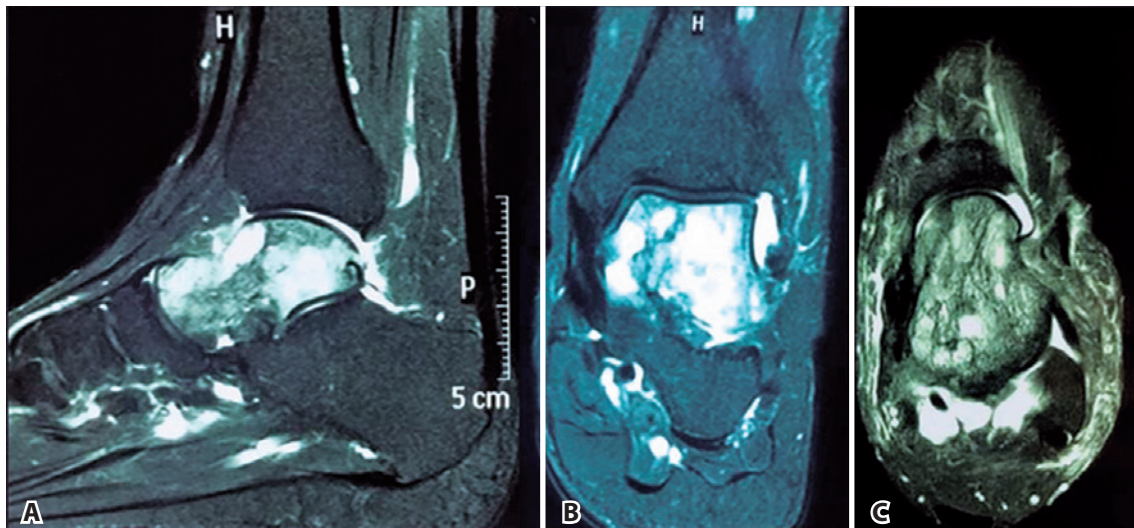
T2-weighted nuclear magnetic resonance images. A) sagittal. B) coronal. C) axial.
